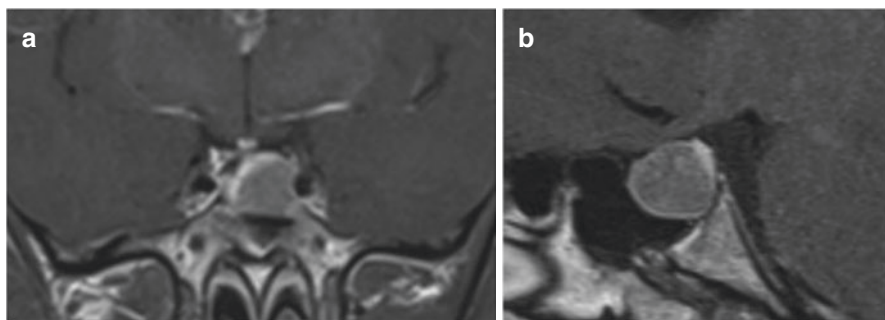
Pituitary MRI images at baseline (coronal (a, left) and sagittal (b, right))
